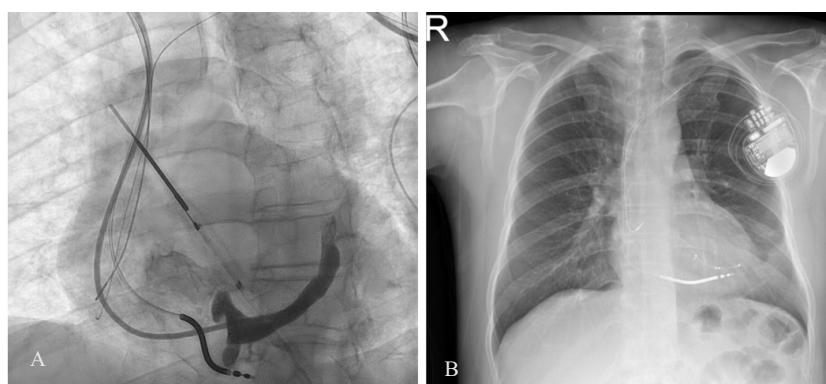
(Fluoroscopy during the procedure and post-procedure PA chest X-ray. (A) Fluoroscopy shows successful cannulation and opacification of venous anatomy in coronary sinus contrast filling. (B) Post-procedure PA chest X-ray shows the CRT-D device, lead placements, and significant angulation of the coronary sinus lead.
